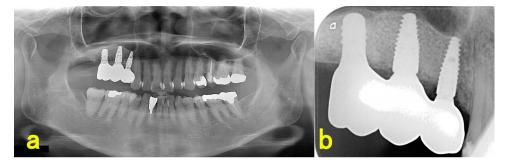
(a) Panoramic radiograph immediately after the placement of the superstructure. (b) Periapical X-ray image at that time.
